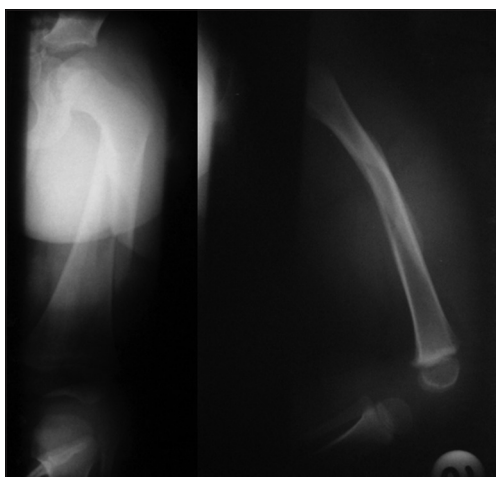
X-ray of thigh with hip and knee joints anteroposterior and lateral views showing femoral fracture in 3 years old child
